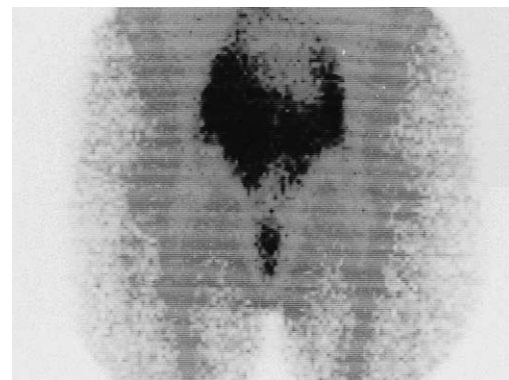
Immunoscintigraphy, planar, anterior view. Accumulation of radiopharmaceutical (Oncoscint) in peritoneal carcinosis.
